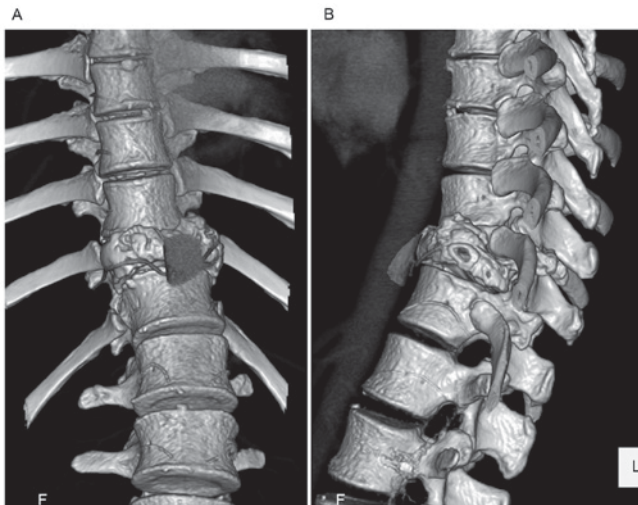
Three-dimensional computed tomography angiography images just prior to surgery. (A) An anterior view. (B) A lateral view. The anterior wall of T11 was collapsed and the edge of the anterior wall overlapped with adjacent vertebrae, which made the resection line irregular.
